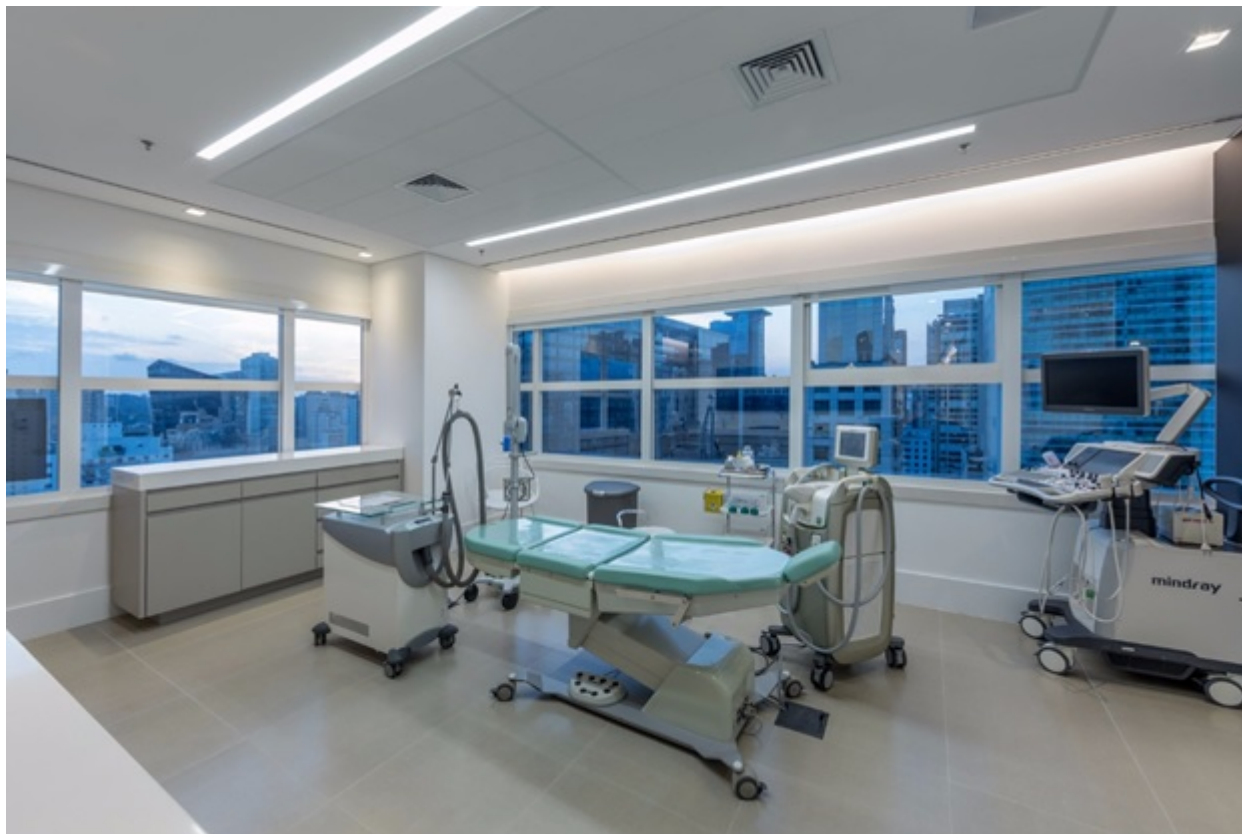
Phlebo-suite is a room prepared for diagnosis and aesthetic vein treatment. Ideally, it should include photo equipment, duplex ultrasound, augmented reality, skin cooler, transdermal laser, and magnification loupe. A complete phlebo-suite may also contain endovenous laser/radiofrequency devices.
